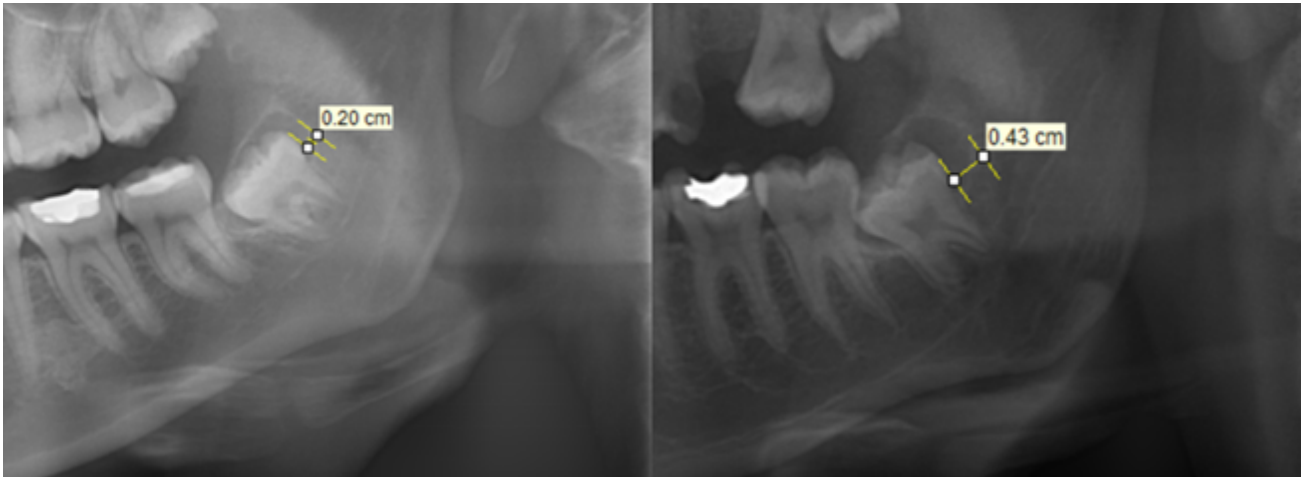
Pericoronal radiolucency was recorded as 'present' in case of pericoronal radiolucency (>3 mm, right side) 'absent' in case of pericoronal radiolucency (<3 mm, left side) associated with impacted permanent tooth on panoramic radiographs.
